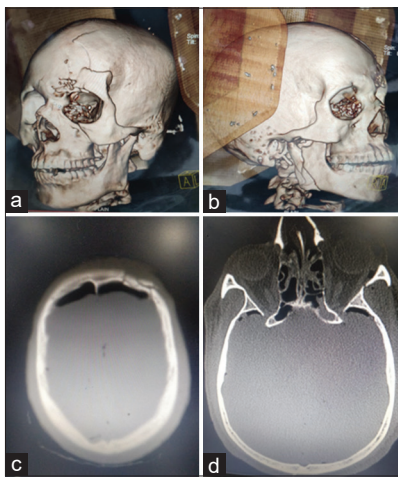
Case of road traffic accident. (a and b) 3D reconstruction of CT showing comminuted fracture in relation to right ramus of mandible left zygomatic complex and frontal bone fracture. (c and d) Axial sections of CT showing pneumocephalus seen in relation to frontal region and anterior mid-brain region
